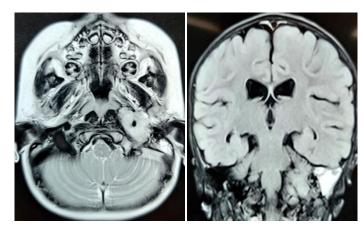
MRI scan showing Left petrous apex mass
